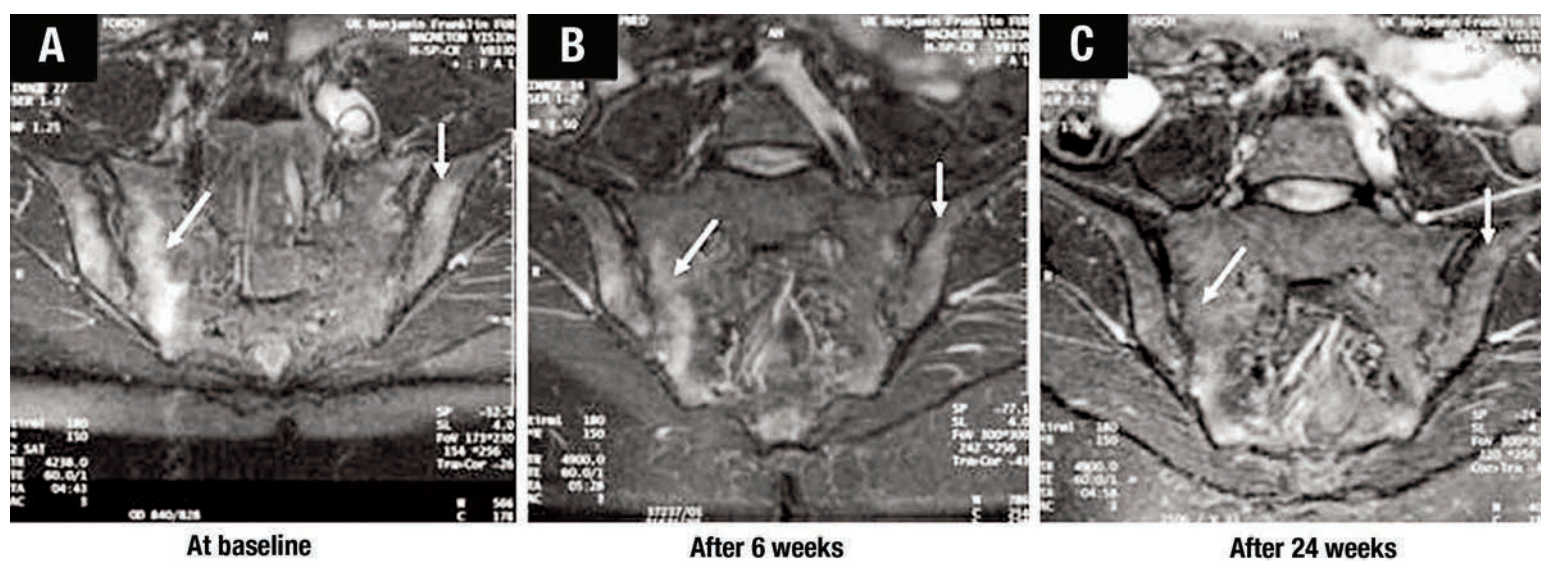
Sacroiliitis MRI response to anti-TNF therapy.
